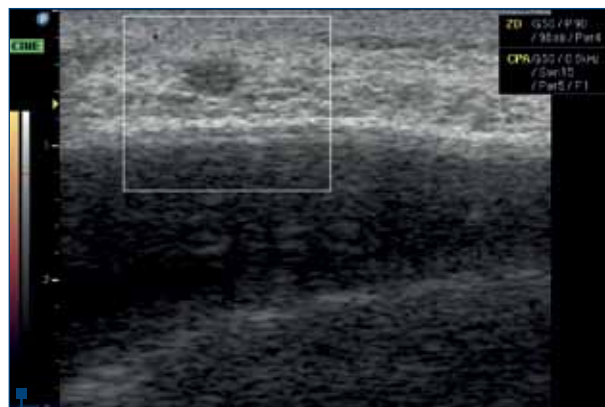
Color Doppler ultrasound revealed no internal vessels
